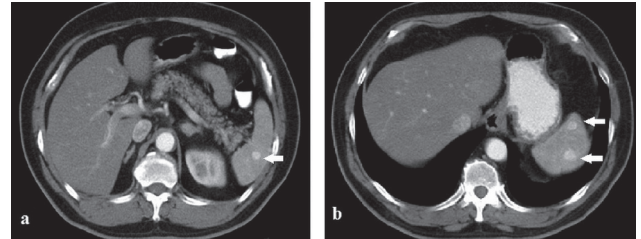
Abdominal computed tomography images showing enhanced mass lesions within the spleen (arrows, a and b).
